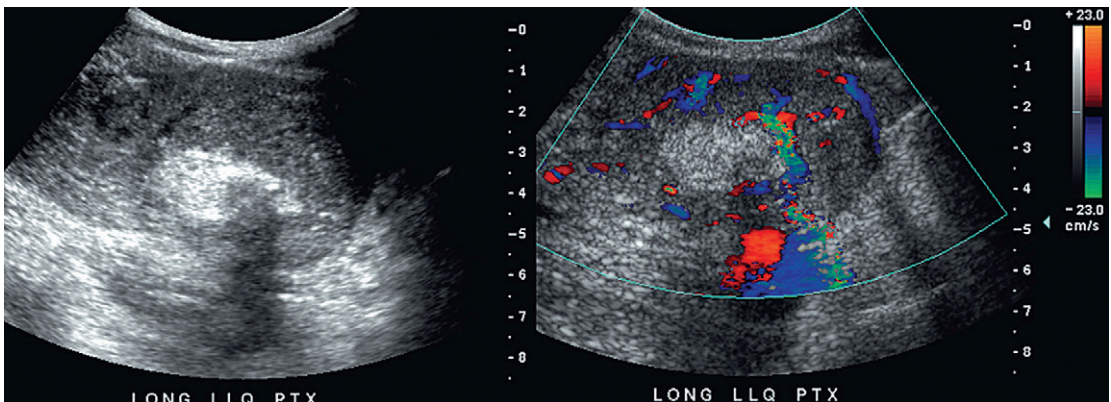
Grey-scale and colour Doppler images of a pancreas transplant reveal an echogenic rounded area with shadowing from gas. Colour Doppler shows some hyperaemia immediately adjacent to this collection. This was a focal pancreatic abscess.
